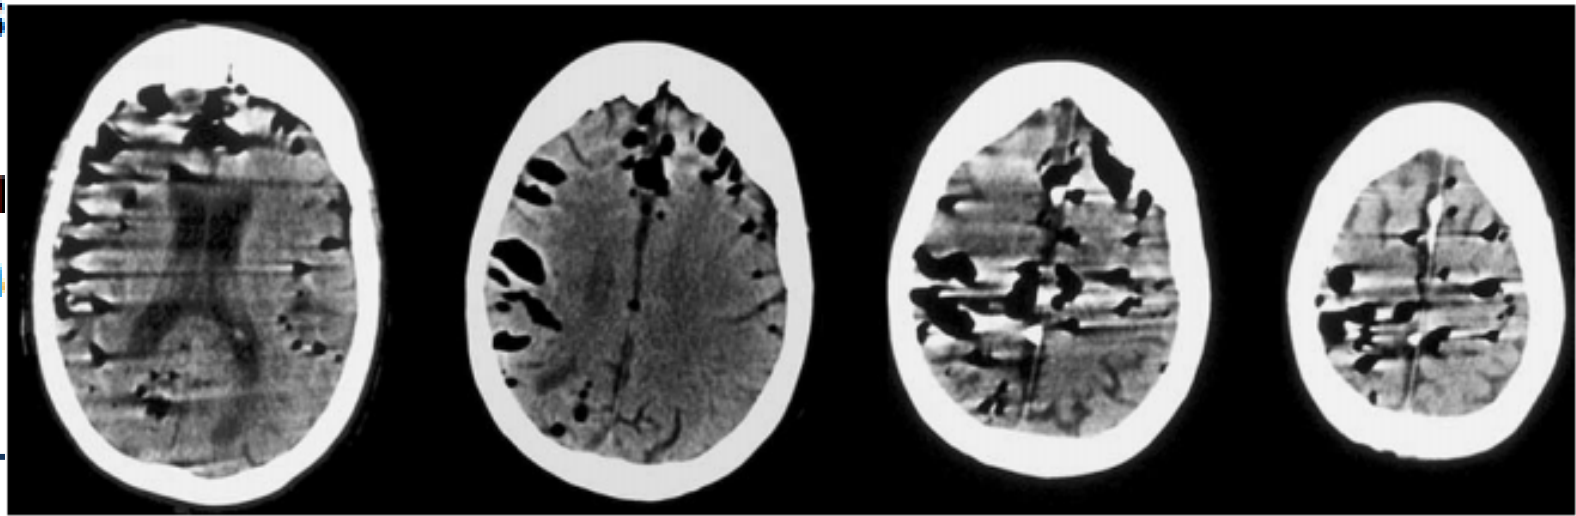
CT-scan after the replacement of 25 ml of CSF with 70 ml of air
